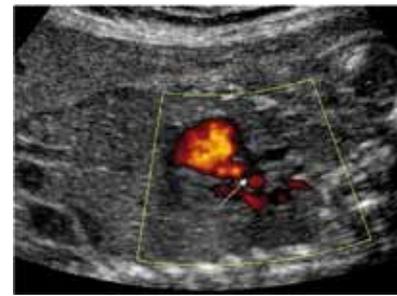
18 weeks of gestation. Hypoplastic left heart syndrome. Power Doppler Mapping. Arrow — hypoplastic aorta ascendens
